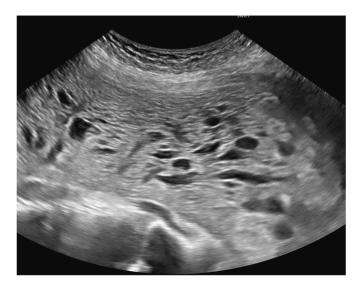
Abdominal ultrasound imaging (sagittal section) showed a giant intrauterine mass with the findings of "snowstorm-like" hypervascularity, which was characterised as a hydatidiform mole.
